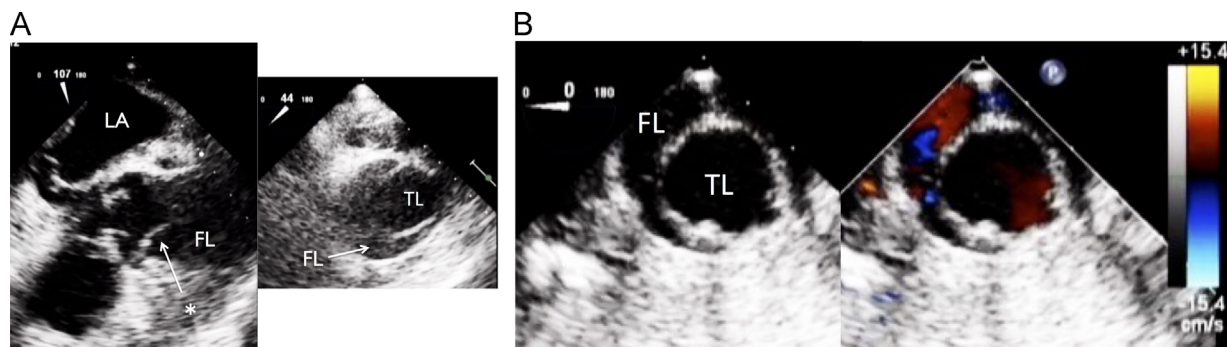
(A) Perioperative transesophageal echocardiograph indicating a Stanford type-A aortic dissection in the midesophageal long-axis view and ascending aortic short-axis view. The asterisk (*) indicates the dissection flap. (B) Perioperative transesophageal echocardiograph indicating a descending aortic dissection in the descending aortic short-axis view. Abbreviations: LA, left atrium; TL, true lumen; FL, false lumen.
